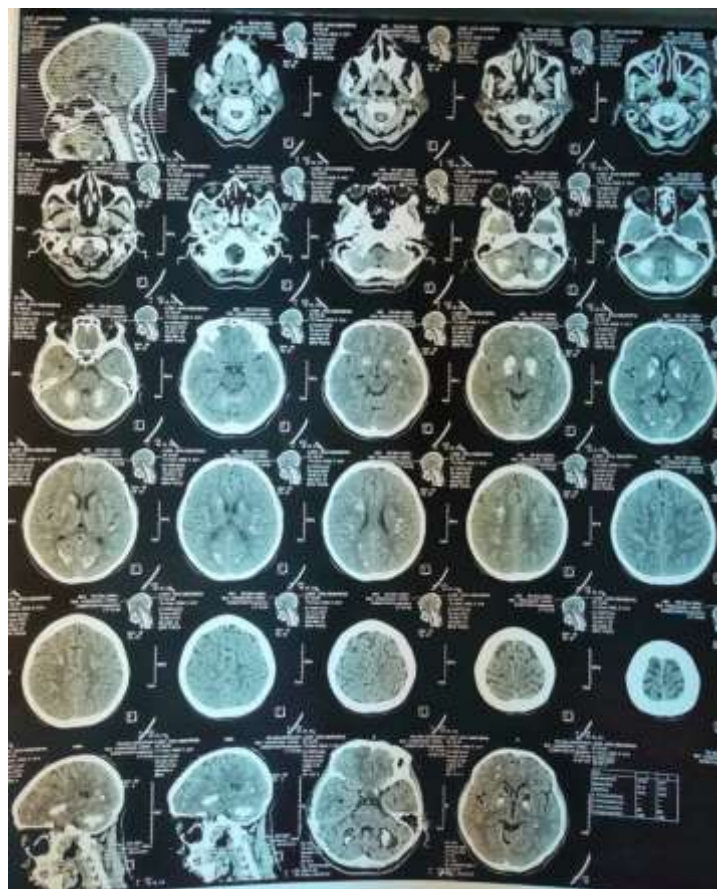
CT scan of the head without contrast in an outside private hospital
